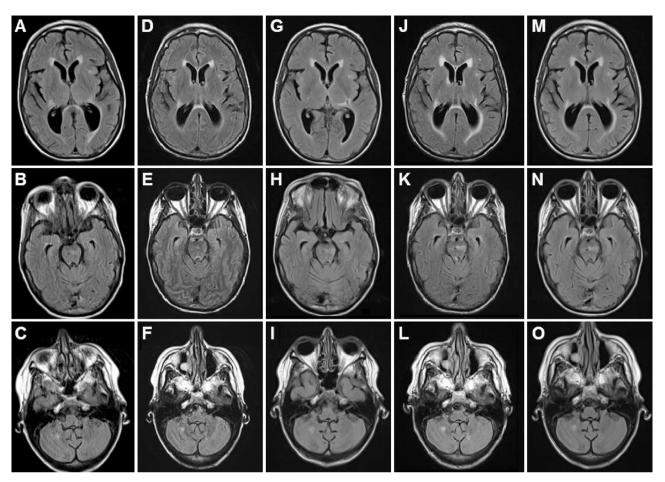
Magnetic resonance imaging (MRI) showing diffuse multi-focal hyperintense lesions on axial T2 fluid-attenuated inversion recovery (FLAIR) sequences on initial presentation (A–C), 3 weeks after presentation (D–F), 6 weeks after presentation (G–I), 5 (J–L) and 8 (M–O) months after presentation.
